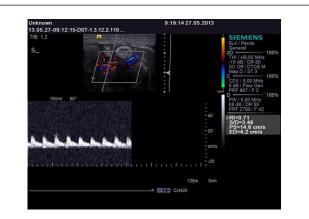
Echogram of the intestinal loop in a neonate, day 5 postop (pulsed-wave Doppler scanning). RI is approaching the normal values.
